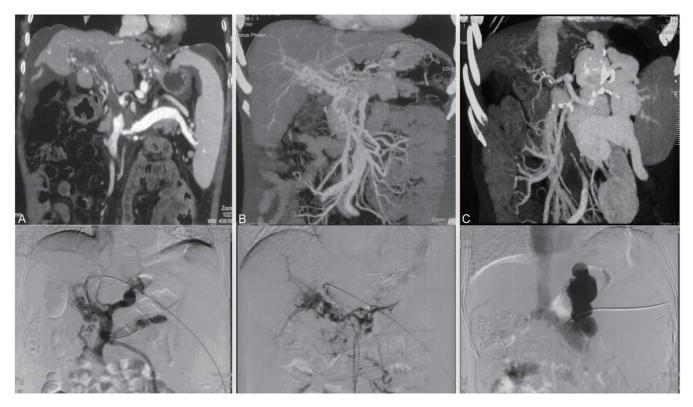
Different degrees of portal vein thrombosis in cirrhosis. (A) Occlusive portal vein thrombosis (PVT) with cavernous transformation without fibrotic cord. The main portal vein was filled with thrombus, but the original lumen structure was visible. There were many spongy collateral vessels around the portal veins. (B) Occlusive PVT with cavernous transformation and fibrotic cord. There were gross portal collaterals without a visible original main portal vein. (C) Occlusive PVT with fibrotic cord without cavernous transformation. The lumen structure of the original main portal vein was replaced by a fibrotic cord. Some portosystemic shunts were formed. Spiral enhanced computed tomography images with multiplanar reconstruction (upper). Digital subtraction angiography images (lower).
